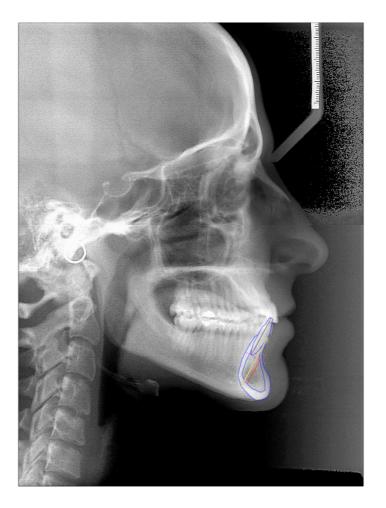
Lateral cephalometric radiograph from patient 3
